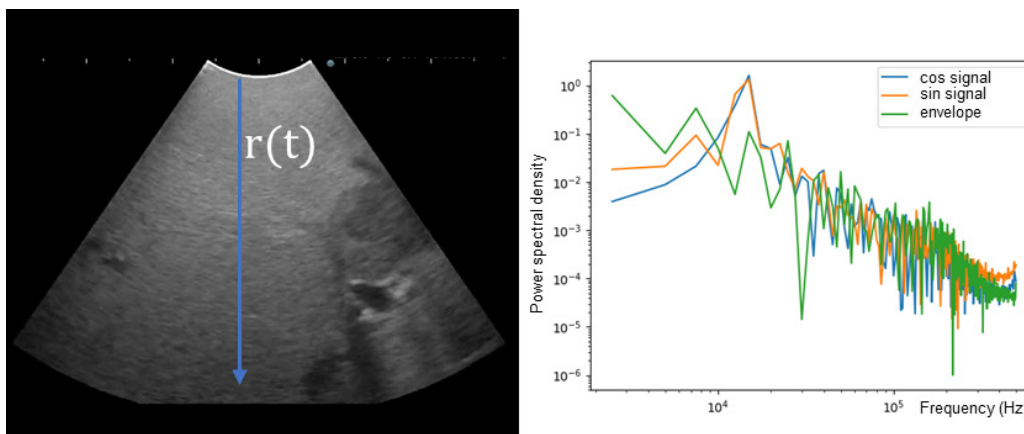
Power spectrum of the reflected ultrasound signal $r(t)$ in ultrasound images of the liver incorporating a power-law shot noise model. The power spectrum was calculated for the cos component, sin component, and envelope of the signal.
